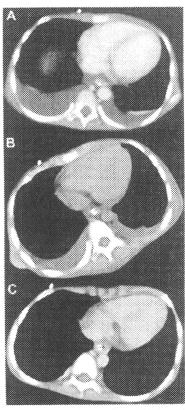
Administration of bevacizumab. Chest CT before (A), 5 days after (B), and 20 days after (C) treatment with bevacizumab.
